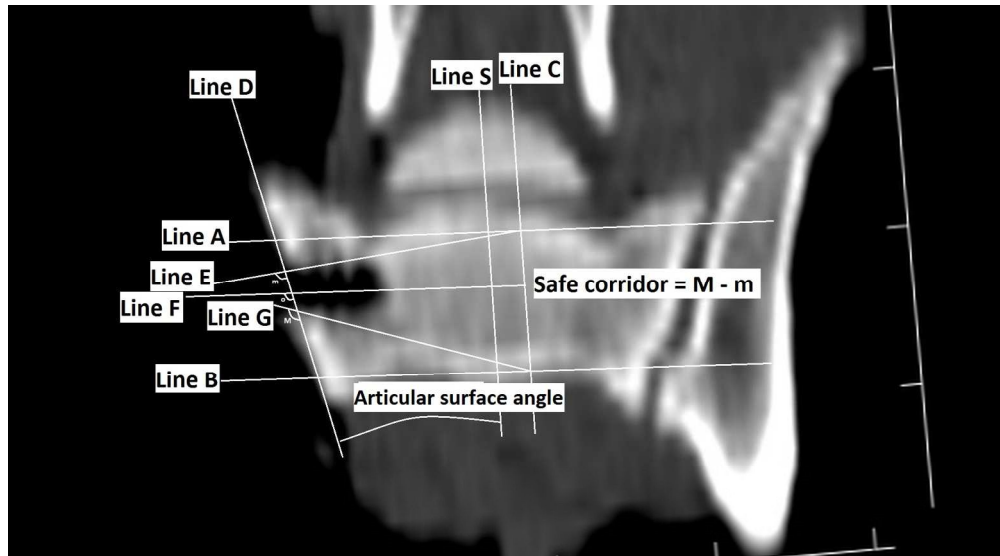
close-up. CT evaluation of the dorsoventral safe corridor in the transverse plane (close-up).
